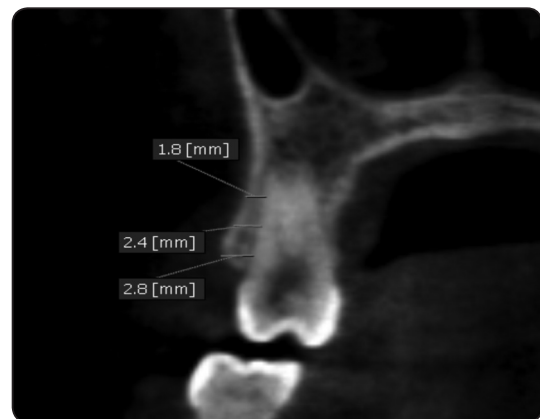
Coronal CBCT image showing measuring the thickness of buccal bone for the right second premolar at cervical, middle, and apical thirds of the root.
